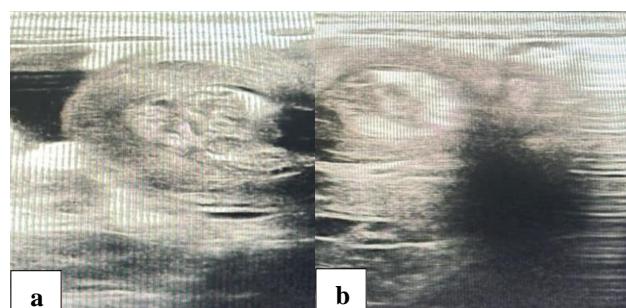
(a and b): Ultrasonography image representing a small segment of telescoping noted in the epigastric region (adjacent to the stomach) with telescoping of mesentery and small bowel.
